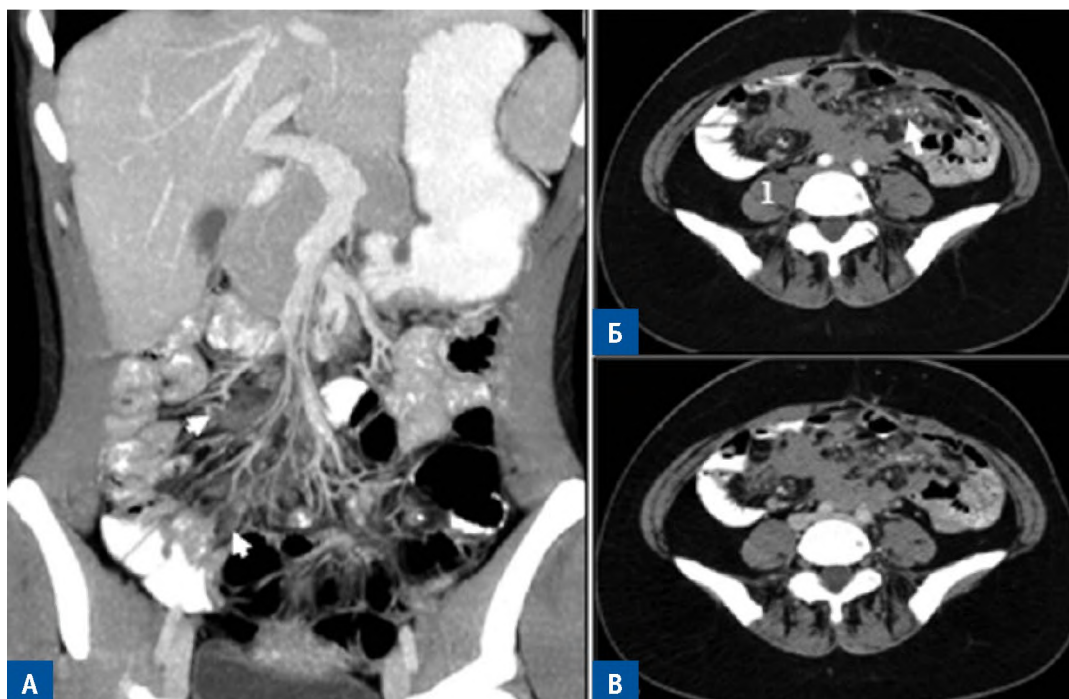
Infiltrative form of desmoid-type fibromatosis of the small intestine mesentery. CT with contrast enhancement. A — coronary tomogram of patient K., 26 years old, VIP-reconstruction; infiltrative growth of DF (arrows) along the mesenteric vessels. B, C — axial tomograms of patient Ts., 50 years old; DF of the mesentery and the root of the small intestine mesentery with the involvement of small intestine loops and mesenteric vessels (arrow); B — arterial phase; no accumulation of contrast agent, DF density close to muscle density (1); C — venous phase; slight accumulation of contrast agent
